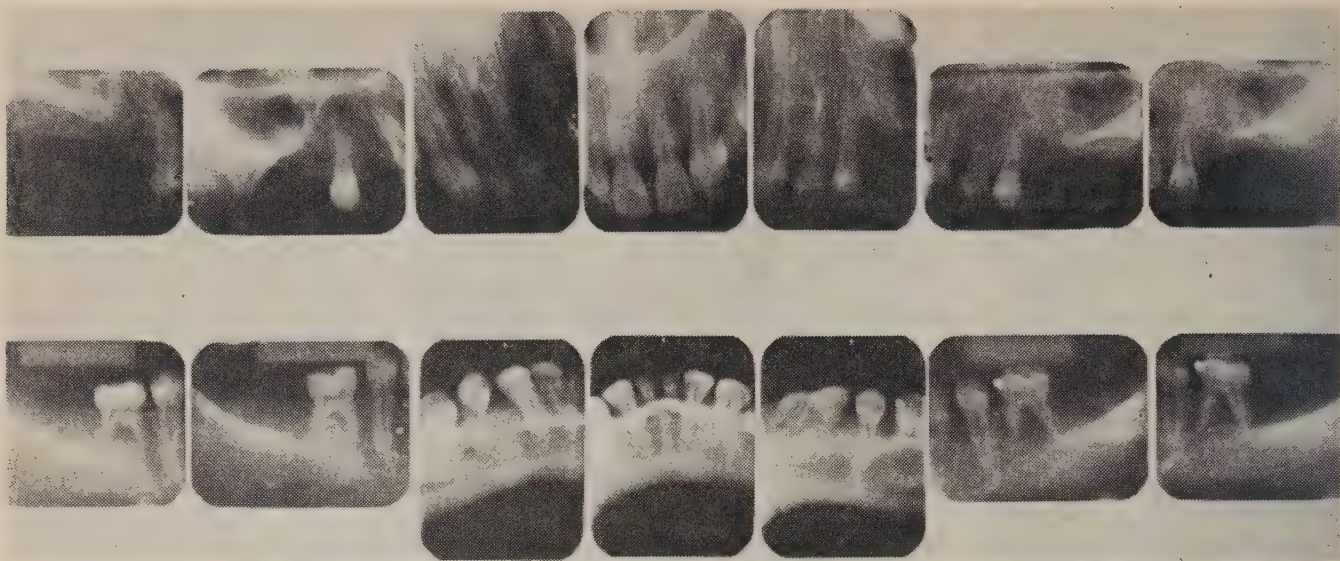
Diagnostic periapical radiographs.
